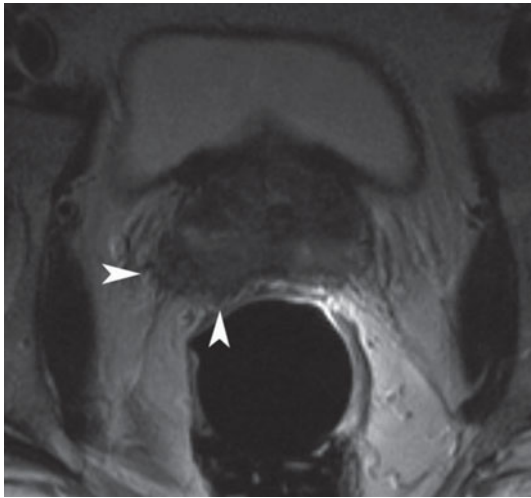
Magnetic resonance. Axial T2-weighted image. Prostatic adenocarcinoma, stage T3a with invasion of the perirectal fat. On the right the lesion interrupts the hypointense signal of the prostatic capsule and extends into the perirectal fat with irregular margins (*arrowheads*)
